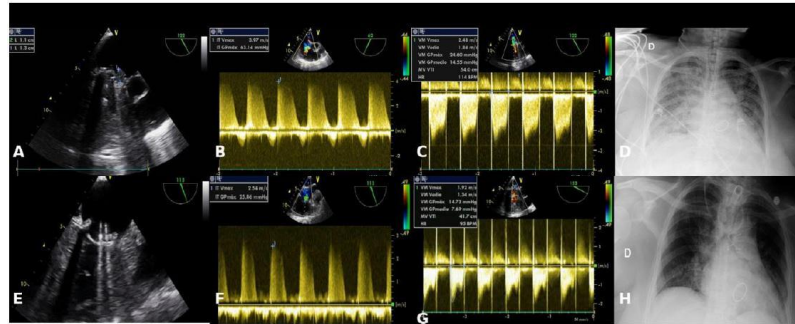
Transesophageal echocardiographic view showing a mechanical disc valve with limited movement of the anterior disc due to an adherent, iso-echogenic, mobile mass (11mm x 13mm), suggestive of a thrombus. Figure 1B: Short-axis view showing mild to moderate tricuspid regurgitation flow by continuous Doppler, with a peak gradient of 63mmHg. Figure 1C: Mitral valve Doppler recording a maximum velocity of 2.48 m/s and a mean gradient of 14.5 mmHg. Figure 1D: Anteroposterior chest radiograph showing diffuse alveolar opacities and cardiomegaly, with postoperative changes from cardiothoracic surgery. Figures 1E-H (post-thrombolysis): show improvement in transvalvular gradients and reduction of pulmonary congestion.
